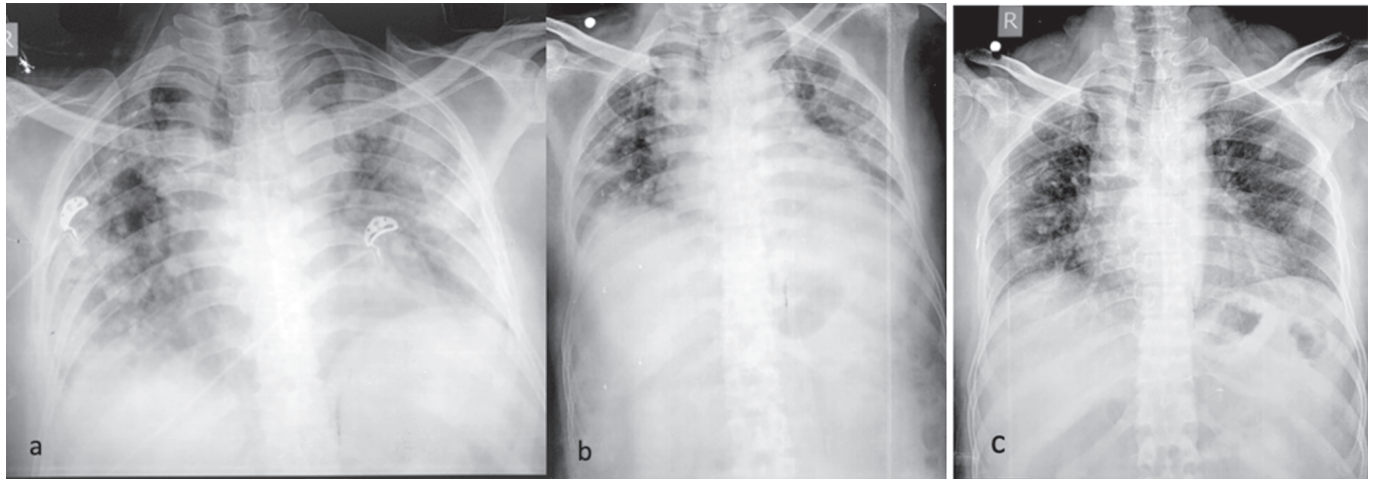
(a) Bilateral peripheral-based multiple opacities with predominant lower lobe involvement; (b) improved chest X-ray just before discharge; (c) no new opacities at the time of re-admission with clinical and virological recurrence of Covid-19
